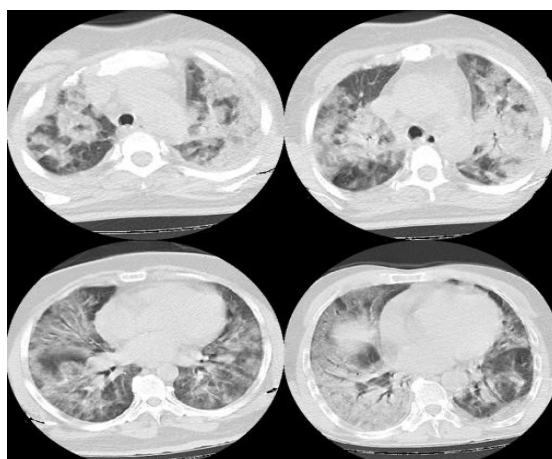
Severe lung involvement image on CT
